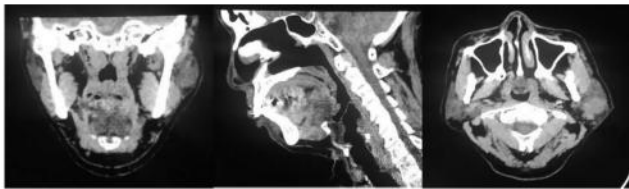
Head and Neck CT Scan without contrast
